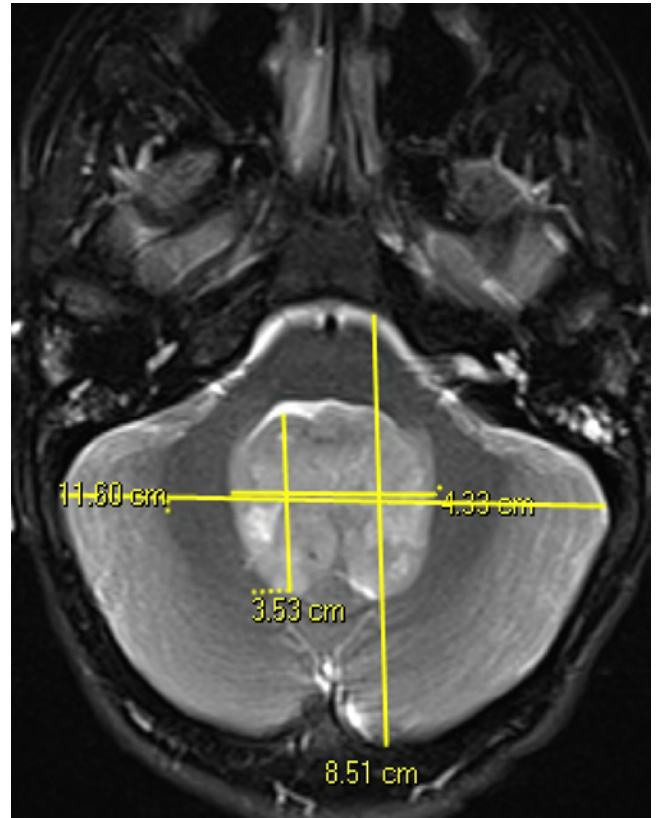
Patient 8. Axial T2-weighted MR image of the brain obtained in a 16-year-old patient with metastatic medulloblastoma. The tumor-to-PF area ratio of 0.15 was calculated by measuring the maximum anteroposterior and transverse diameters of both the tumor and the PF, and dividing the tumor dimensions by the PF dimensions.
